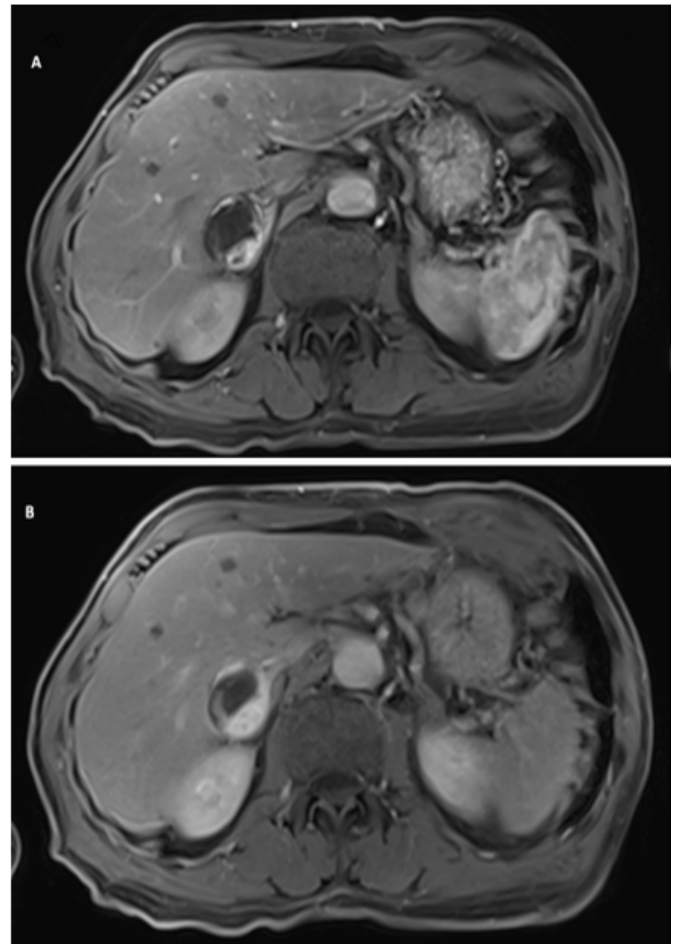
Arterial-phase (A) and delayed-phase (B) contrast-enhanced MRI demonstrating peripheral enhancement of the right adrenal lesion with progressive centripetal filling.
